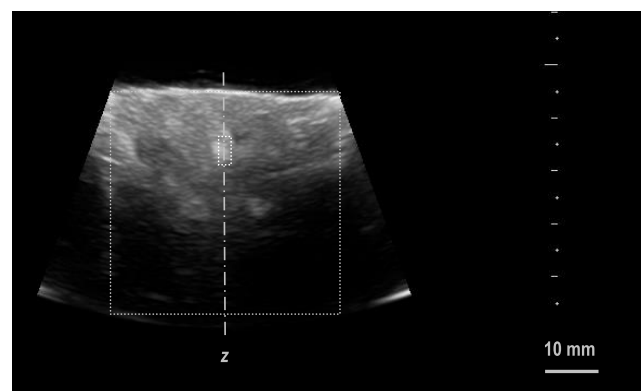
Ultrasound image of the axial section (xz) of the central necrotic lesion created by the HIFU beam (with a 3.21 MHz frequency, 0.3 s pulse duration and 0.6 duty-cycle) in the tissue sample at a 12.6 mm depth below the tissue surface. The tissue chamber outline is marked with a larger rectangle, the hyper-echogenic area is marked with a small rectangle.
